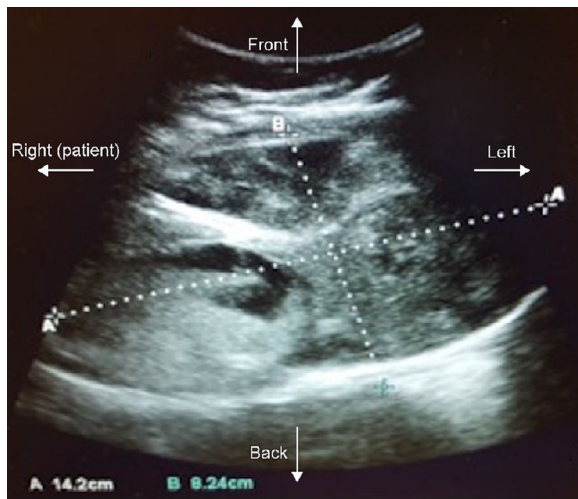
Ultrasound image of the heterogeneous structure identified before the C-section.
